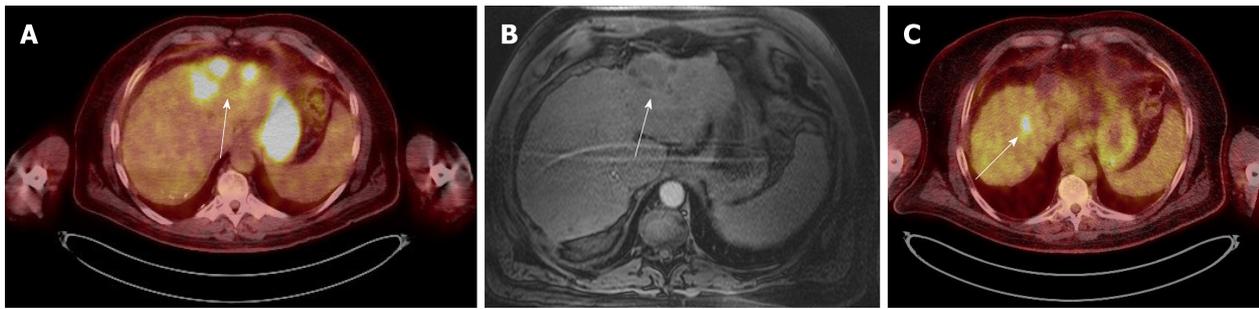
Case 1. A: Positron emission tomography scan: the white arrow shows the area of multiple foci of fludeoxyglucose uptake in the treated area; B: Multi-phase magnetic resonance imaging scan: it shows no arterial enhancement in the same area during the arterial phase; C: Positron emission tomography scan: the arrow indicates an area of fludeoxyglucose uptake, indicating another residual tumor.
